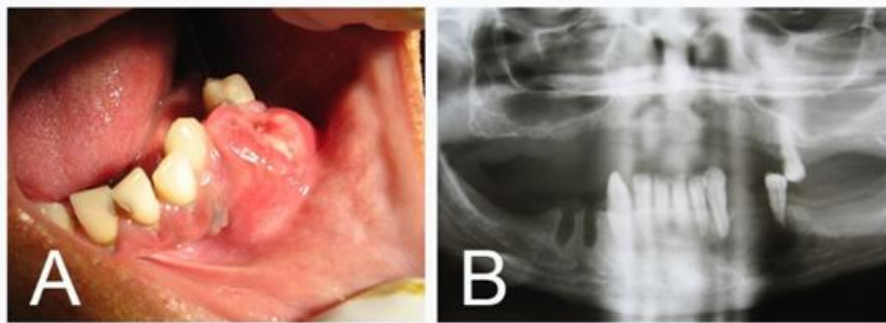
A. Intraoral aspect of the lesion associated with teeth 33 and 35. B. Panoramic radiograph with a radiolucent lesion, with irregular contour, on the left side of the mandible and external root resorption on teeth 33 and 35.
